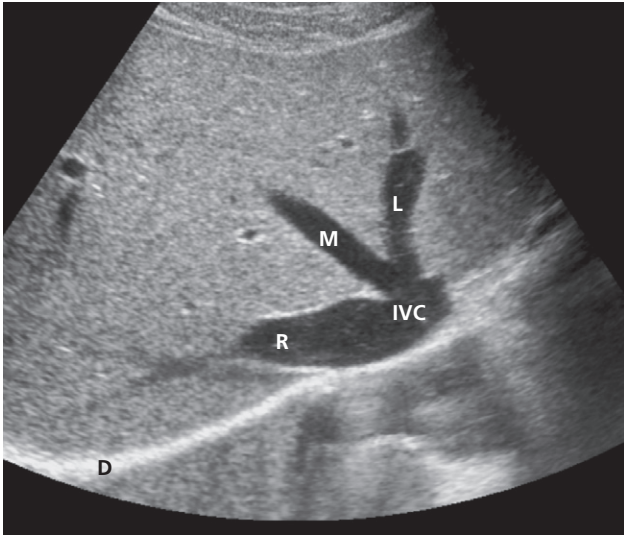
Ultrasound of normal liver. Transverse scan through the superior portion of the liver showing the right (R), middle (M) and left (L) hepatic veins draining into the inferior vena cava (IVC) as it penetrates the diaphragm (D).
